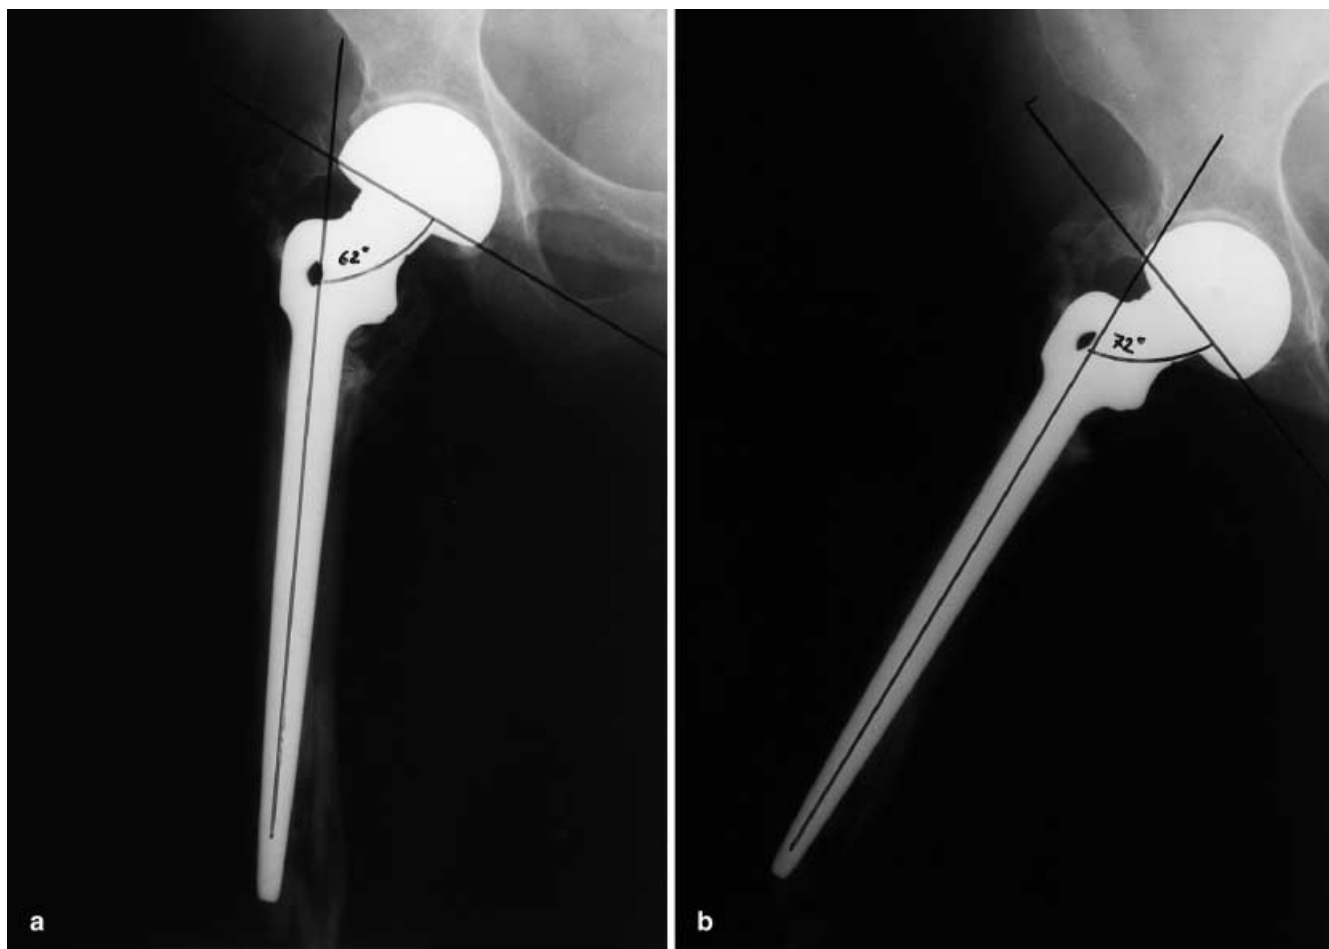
a Pre-operative X-ray. b Postoperative X-ray at 36 months
